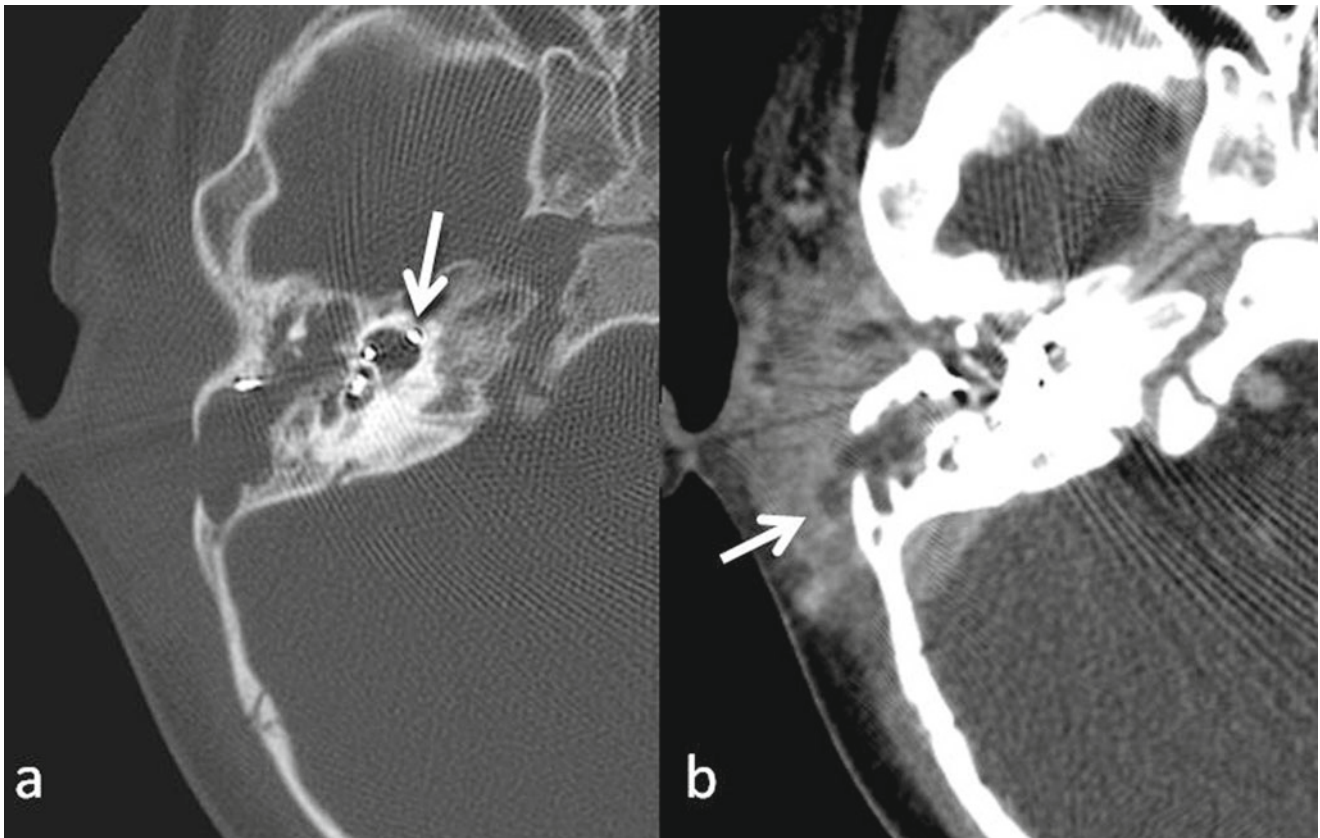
Subperiosteal abscess 1 year after implantation. (a) Axial CT of right ear demonstrates swelling of peri-auricular soft tissue, surgical defect in cortical mastoid bone and opacified mastoid and middle ear. The
